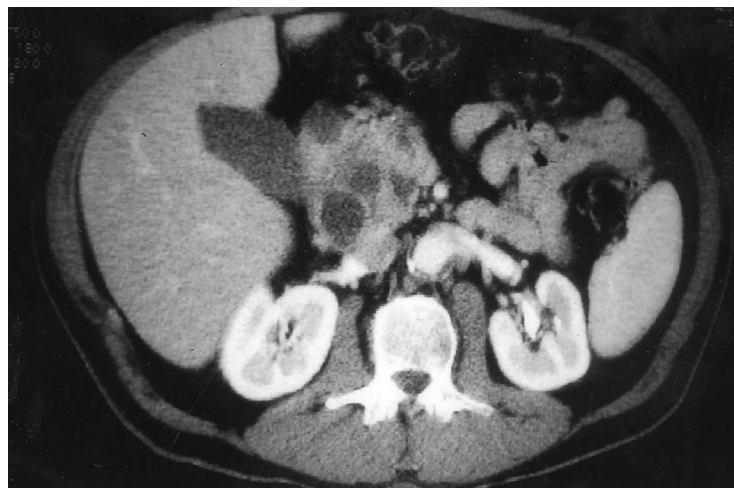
Computed tomography scan showing multiple pseudocysts in pancreatic head.
